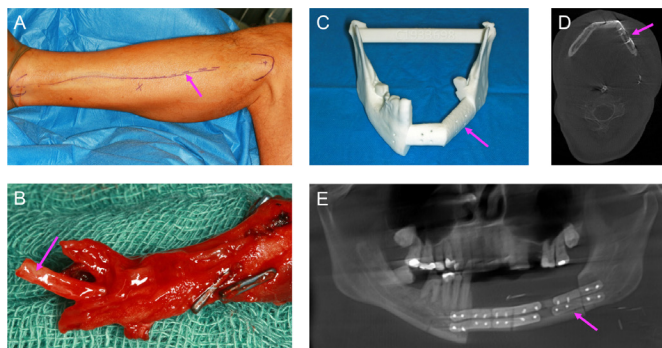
(A) Left lower leg: surgical marks (arrow) for removal of the fibula graft. (B) Microvascular-anastomosed two-segment fibula graft. The vascular stumps (arrows) in the left lower leg were anastomosed with the ipsilateral facial artery and a lateral branch of the internal jugular vein. (C) Individual resection template (arrow) created using virtual surgical planning. Osteosynthesis with computer-aided design and computer-aided manufactured miniplates was performed. Postoperative control (D) CT and (E) panoramic radiography. The fibula graft is indicated by an arrow.
